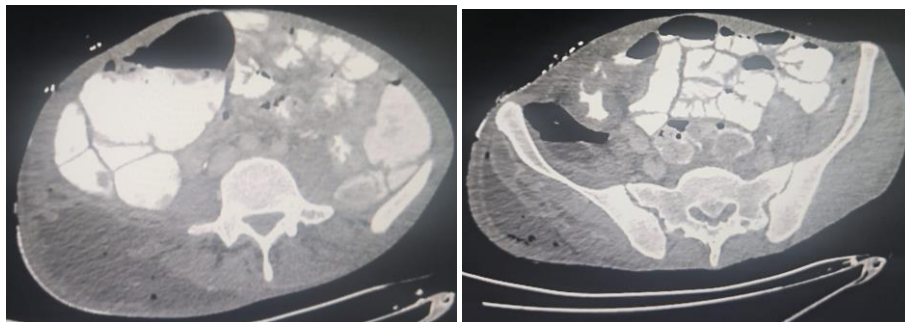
CT imaging demonstrated a collection involving the right iliopsoas muscle, associated with ipsilateral necrotizing fasciitis of the thigh.
